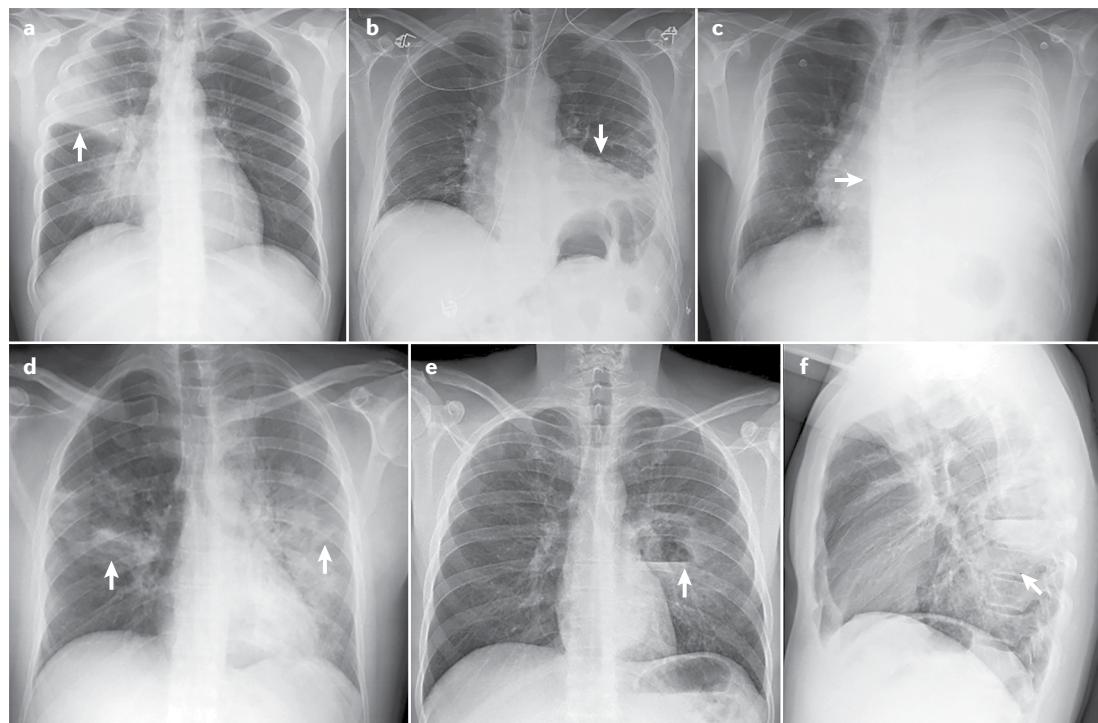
Associated features of pneumonia on plain radiography. Pneumonia in upper right lobe (arrow) (part a); pleural effusion on the left side (arrow) (part b); massive pleural effusion in the left lung (arrow) (part c); bilateral pneumonia (arrows) (part d); lateral image showing left parahilar cavitation with air–fluid level in the lower left lobe (arrow) (part e); front-to-back image in the same individual as in part e.
